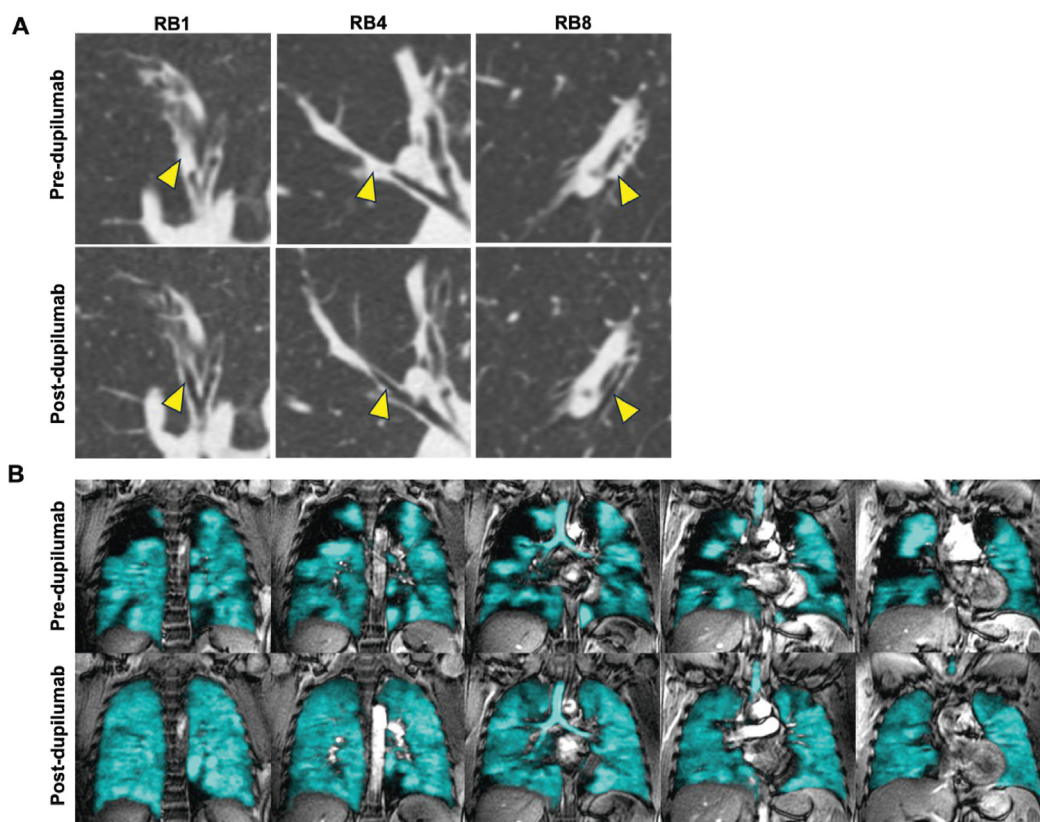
CT images of mucus and Xe^{129} MRI images of ventilation before and after treatment with dupilumab. Panel A shows the change in mucus plugs in coronal (RB1 and RB8) and axial (RB4) planes of CT imaging performed in a 40-year-old male between baseline and after 16 weeks of treatment with dupilumab. The yellow arrows in the superior panel indicate complete intraluminal occlusion corresponding with mucus plugs, which were resolved after the administration of dupilumab (inferior panel). Panel B shows the change in Xe^{129} ventilation MRI (cyan), with a significant reduction in ventilation defect percentage (VDP) from 13% (superior panel) to 3% (inferior panel), matching with the remarkable reduction in mucus burden (CT mucus score from 13 to 3).
